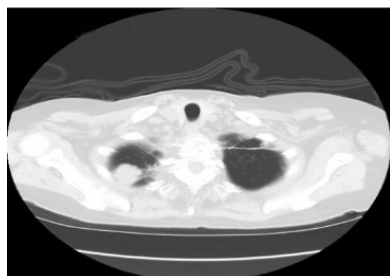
A chest CT scan showed the presence of a right upper lobe metastatic tumor.
